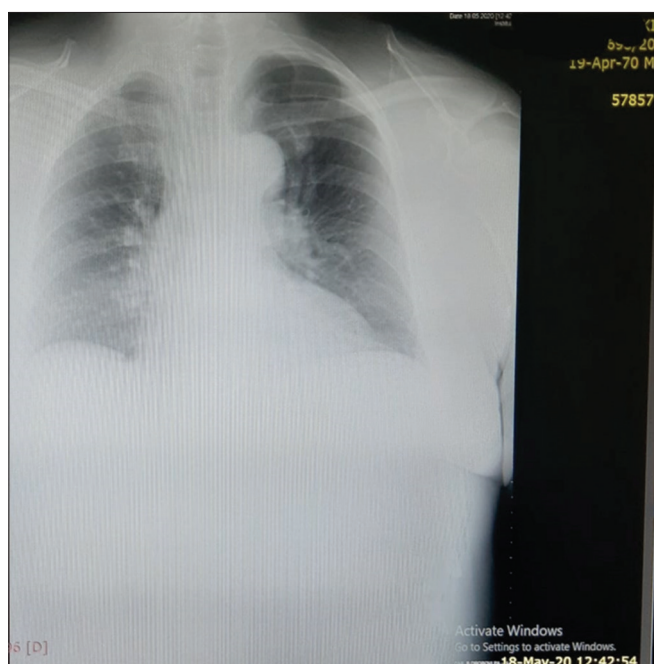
Findings resolved (chest X-ray after 24 days)
